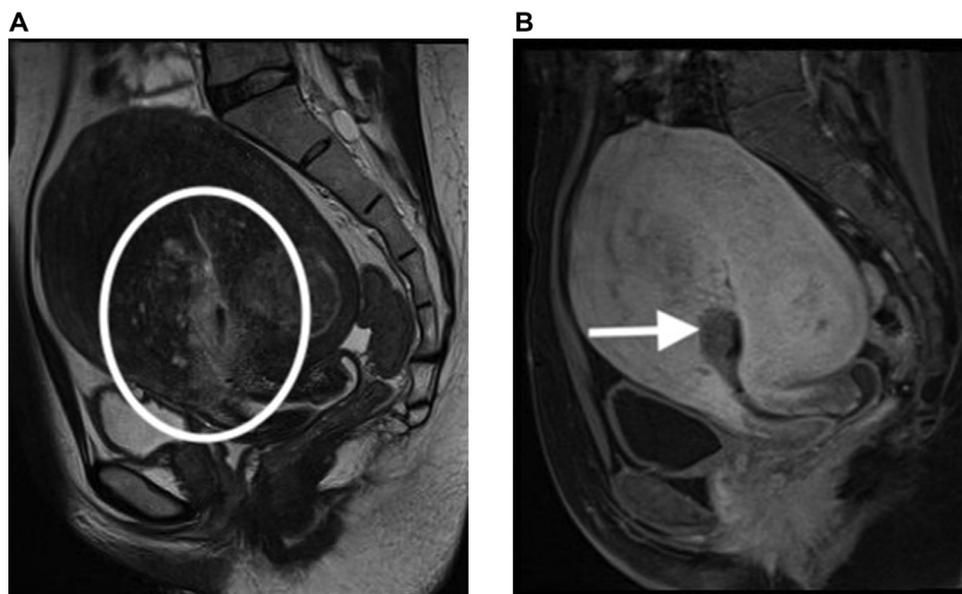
50-year-old woman. Hysterectomy showed Stage 1A endometrioid cancer limited to the endometrium and adenomyosis. (A) Sagittal T2-weighted sequence shows poorly defined high signal thickening of the endometrium in the body and lower uterine segment surrounded by adenomyosis. (B) Sagittal T1-weighted + gadolinium sequence shows hypovascular well-defined focal thickening (arrow) of the endometrium in the lower uterine segment.
